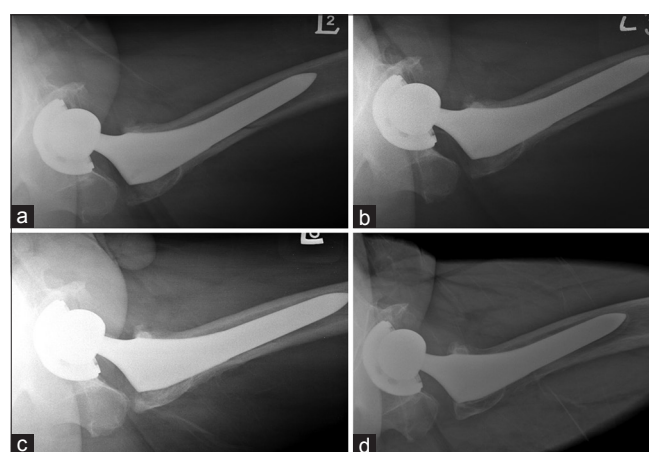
Cross-table lateral hip radiographs of a 62-year-old male show a Type B2 intraoperative periprosthetic femoral fracture (a-d). (a) Followup radiographs show progressive decreasing radiolucent line to the point of complete disappearance. Immediate postoperative period. (b) Postoperative 3 months. (c) Postoperative 6 months. (d) Postoperative 3 years
